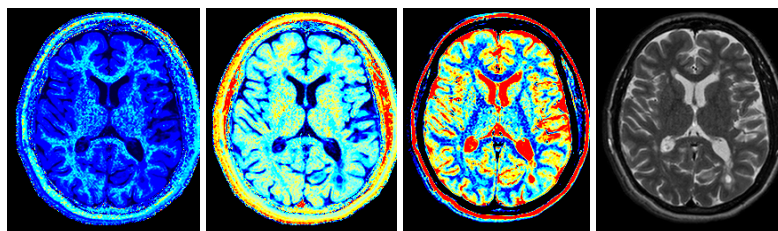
Patient brain: R1 map (scale 0-3 s^{-1}), R2 map (scale 0-2 s^{-1}), PD map scale (50-100% water). The last image shows a T2-weighted image as reference.
